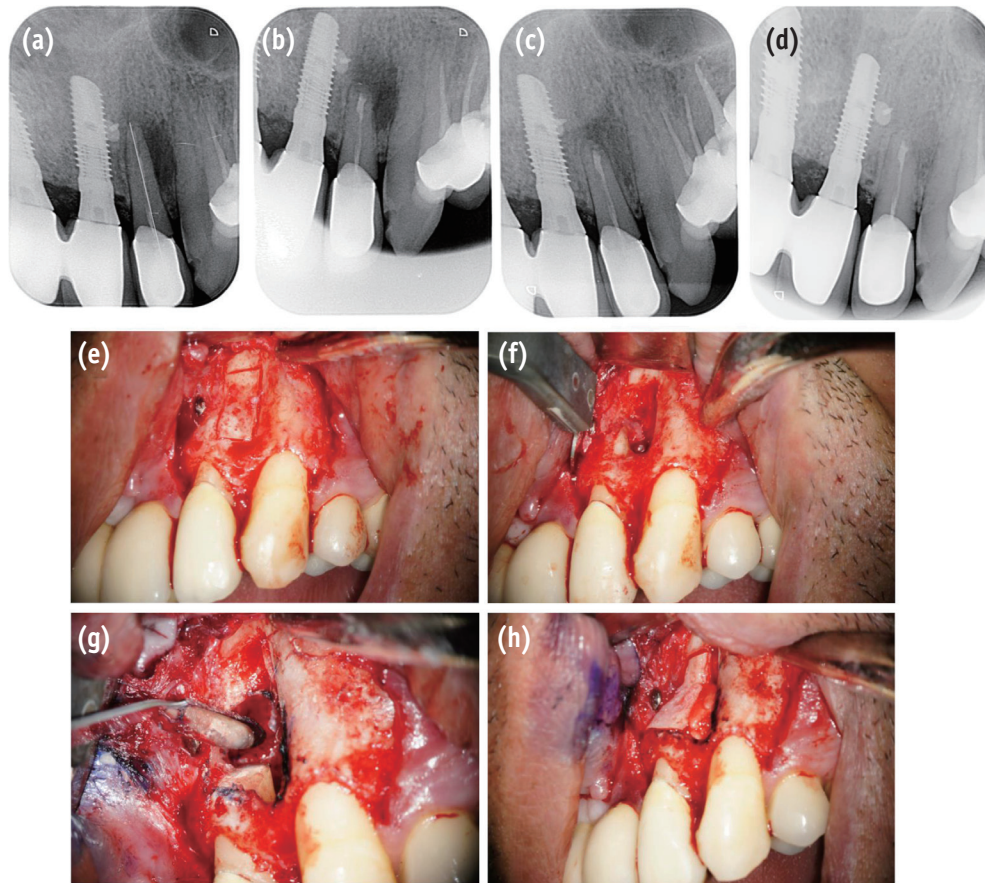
Treatment radiographs and clinical pictures of Case 1. (a) Pre-operative radiograph with measurement tool; (b) Post-operative radiographs; (c) 9 month follow-up radiograph; (d) 18 month follow-up radiograph; (e) Piezoelectrically created bony window (magnification, x8); (f) Bony window osteotomy exposing the lesion site; (g) Root-end filling with white MTA and a clean osteotomy site; (h) Bony window repositioned.
